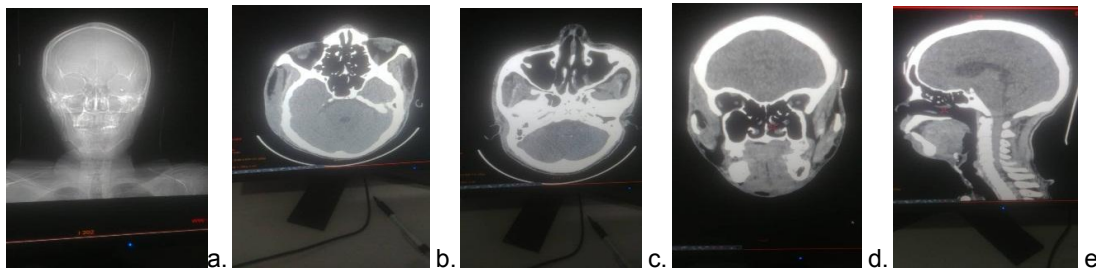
Computed tomographic scan of the 60 year old male, who presented with anterior neck wound and unconsciousness, who tested positive to COVID 19 virus infection
